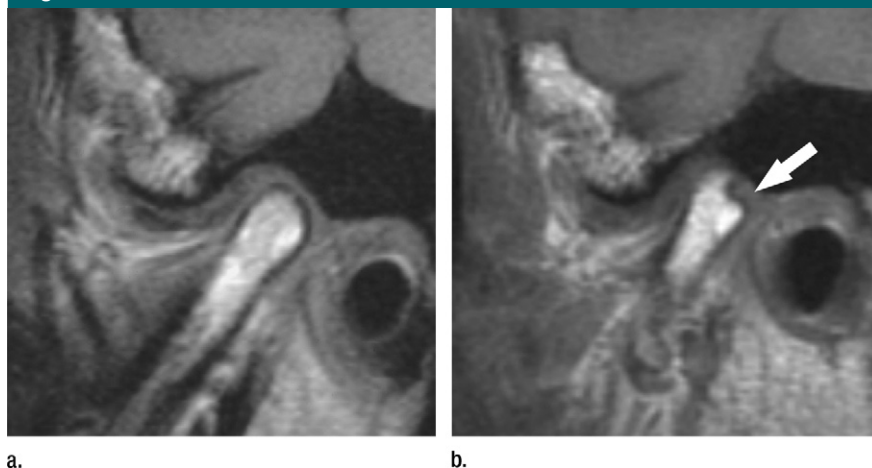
MR images show development of structural bone changes in a 60-year-old woman (45 years old at study inception). T1-weighted sagittal images obtained in closed-mouth position at (a) inception (480/15) and (b) 15-year follow-up (420/10). Note the concavity in the posterior part of the condyle at the 15-year follow-up (arrow, b).
